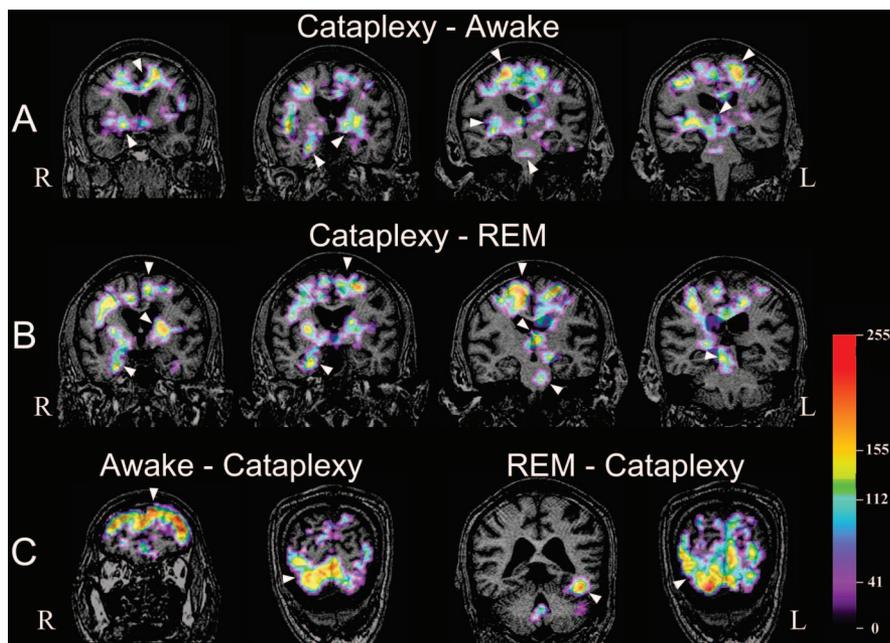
SPECT subtraction results. (A) Hyperperfusion in bilateral premotor cortices, cingulate gyri, sensorimotor cortices, basal ganglia, right amygdala/hippocampus, right insula, both thalami, and brainstem during cataplectic episode compared to baseline awake period (brain SPECT during cataplexy – brain SPECT during baseline awake period). (B) Hyperperfusion in sensorimotor cortices, cingulate gyri, basal ganglia, thalami, right amygdala/hippocampus, midbrain, and pons during cataplexy compared to REM sleep (brain SPECT during cataplexy – brain SPECT during REM sleep). (C, left two images) Hyperperfusion in prefrontal cortices and occipital lobes during awake period compared to cataplexy (brain SPECT during awake period – brain SPECT during cataplexy). (C, right two images) Hyperperfusion in left posterior basal temporal cortex and bilateral occipital lobes during REM sleep compared to cataplexy attack (brain SPECT during REM sleep – brain SPECT during cataplexy). Small arrowheads indicate brain structures described.
